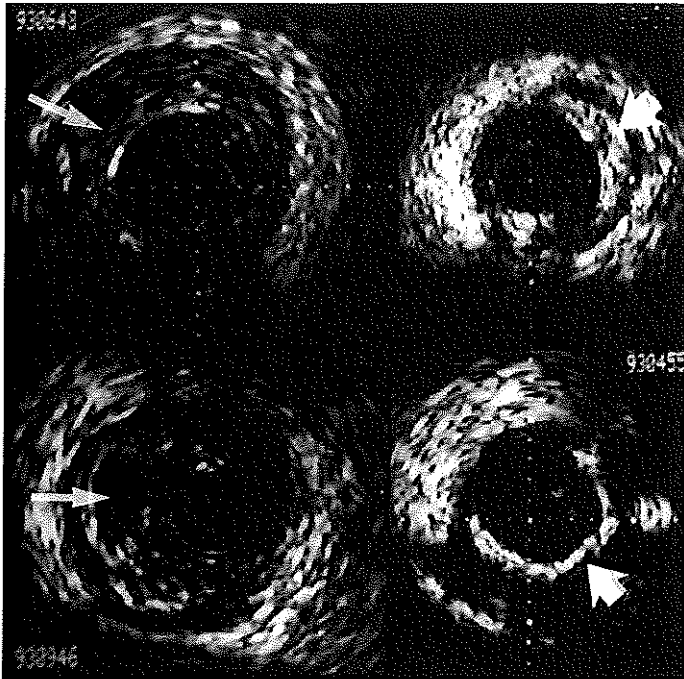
Intracoronary ultrasound images from diseased coronary arteries demonstrating: upper left panel. An eccentric, soft, weakly echo reflective plaque (arrow). Lower left panel. An eccentric, soft, weakly echo reflective, plaque with a 'lipid lake' (arrow). Upper right panel. A hard, strongly echogenic, fibrous plaque (arrow) extending from the 12 to the 5 o'clock positions. Lower right panel. A rim of superficial calcification (arrow), extending from the 1 to the 9 o'clock positions. Note the marked acoustic shadowing behind it.
